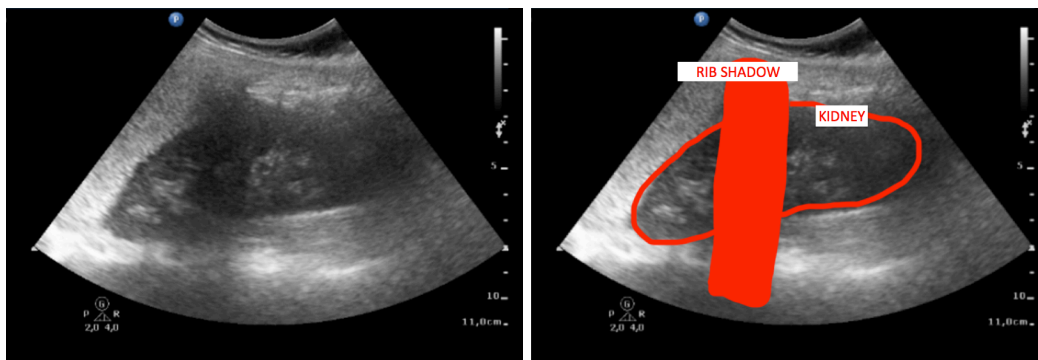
Ultrasonographic image of the left kidney, acoustic shadowing caused by a rib.
